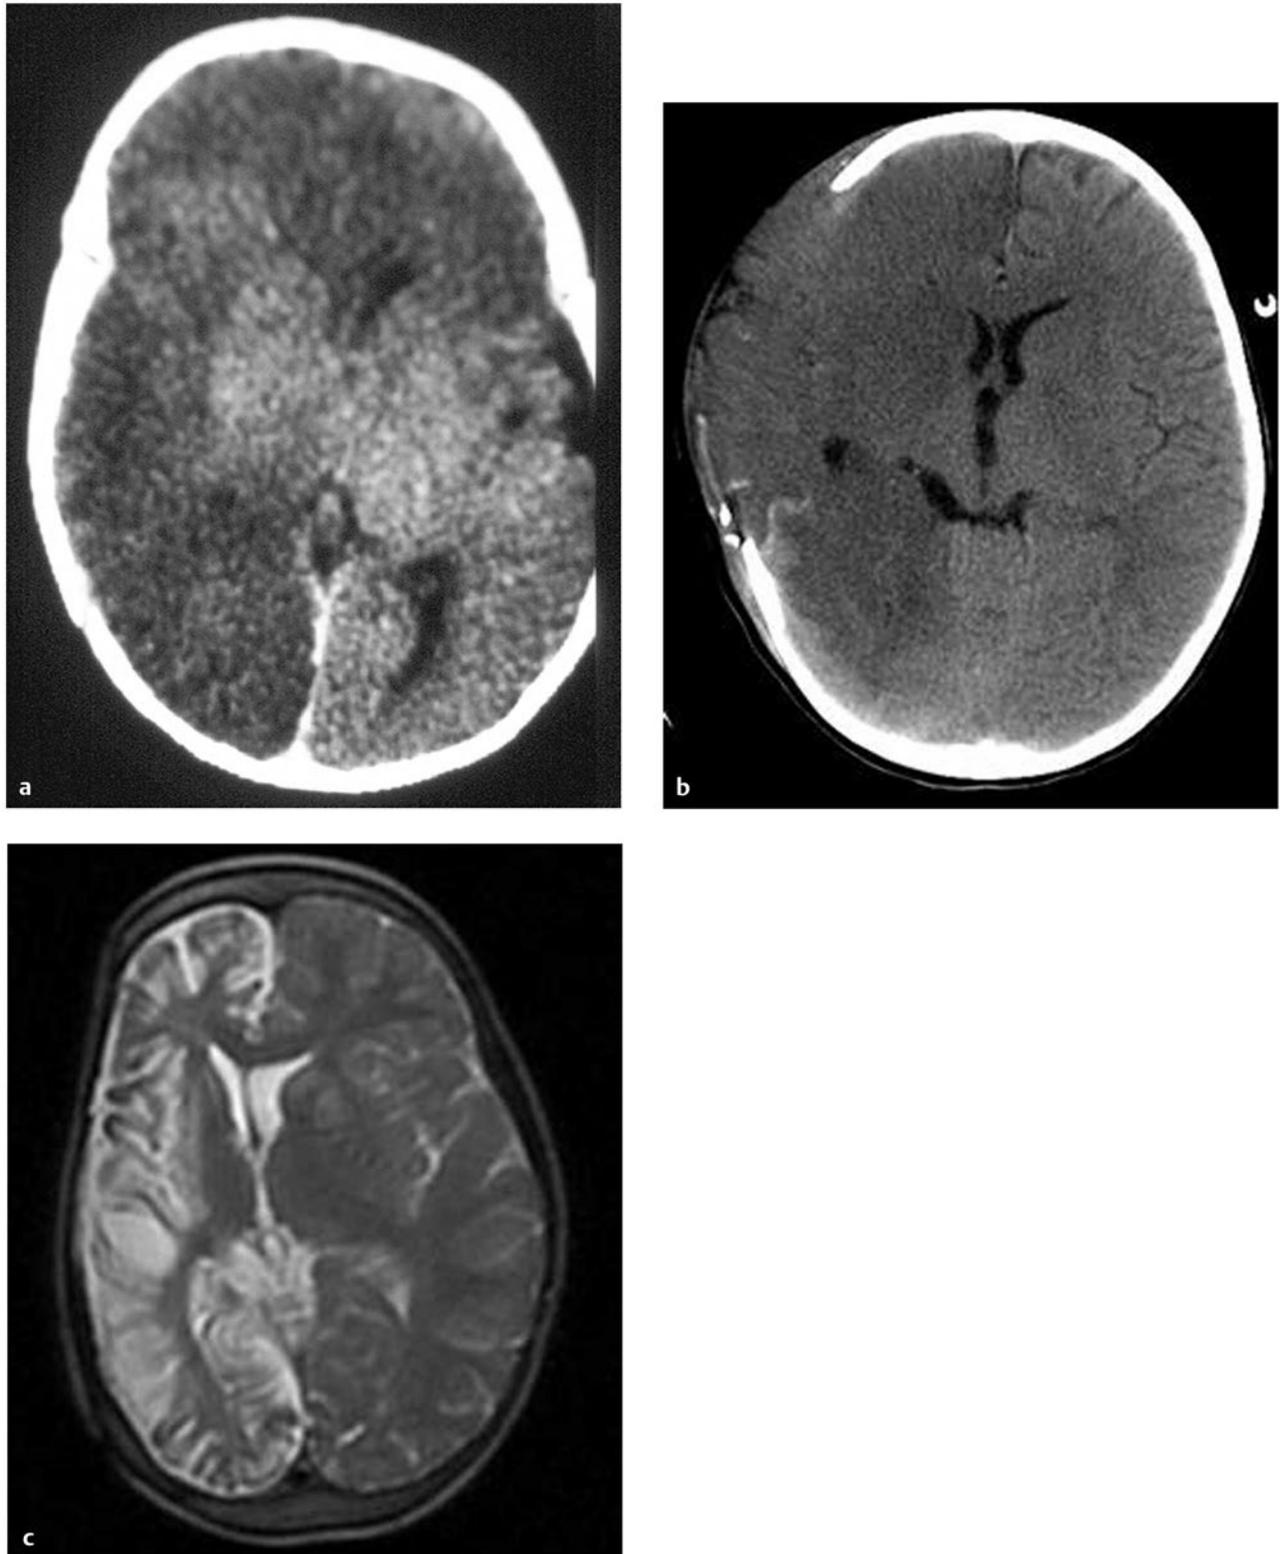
(a) Unenhanced axial computed tomographic (CT) scan showing unilateral hypodensity of the entire hemisphere (“big black brain”) with involvement of the contralateral medial frontal lobe in a child with inflicted injury, likely reflecting subfalcine herniation. (b) CT scan in a child with inflicted injury treated acutely with cranial decompression. (c) Rapid T2 magnetic resonance image 2 years later. Note preservation of the contralateral frontal lobe.
